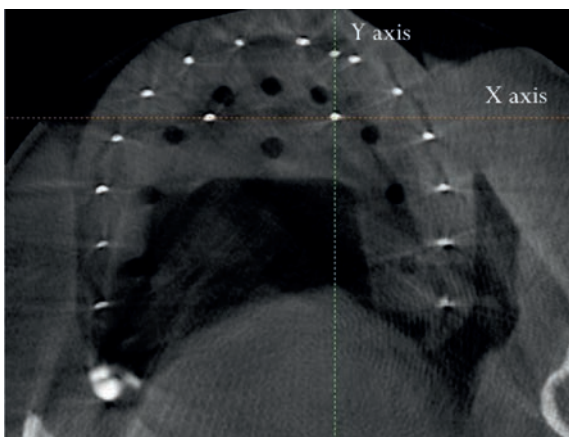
The X- and Y-axis on the CBCT image.
